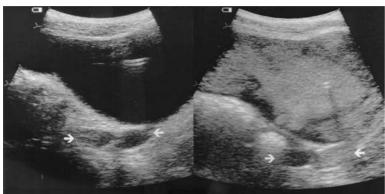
VUR on sonographic cystogram (courtesy of K. Darge).
